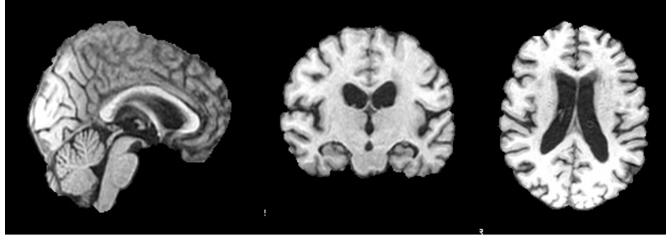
MRI after slicing
